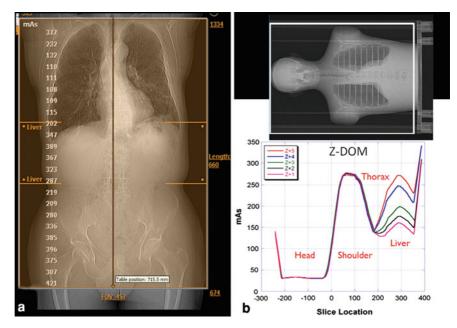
a Surview image and definition of the scan region. b The Water Equivalent Diameter WED(z) along the table direction is measured from the Surview image. WED_{max} is compared to the reference diameter to scale the X-ray exposure. In this example, DoseRight ACS recommends an exposure of 210 mAs for WED_{max} = 38 cm. WED(z) profile is used to modulate the exposure (mAs) for each table position with DoseRight Z-DOM. c Coronal reformat of the reconstructed axial images shows that DoseRight Z-DOM does not adapt the tube current to maintain a
